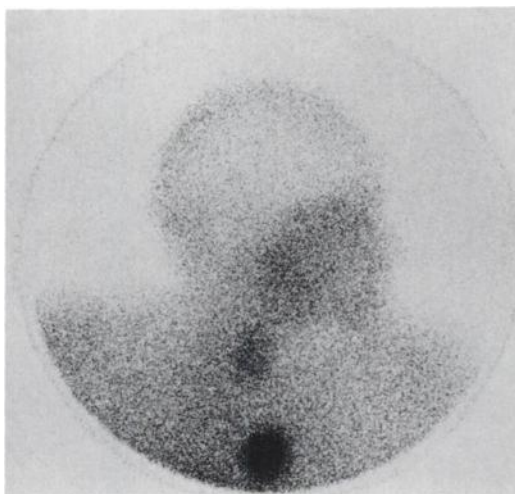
Pentetretotide scintigraph of the right lateral part of head and upper part of the chest (anterior view) shows an intrathoracic hot spot under the usual thyroid gland activity.
